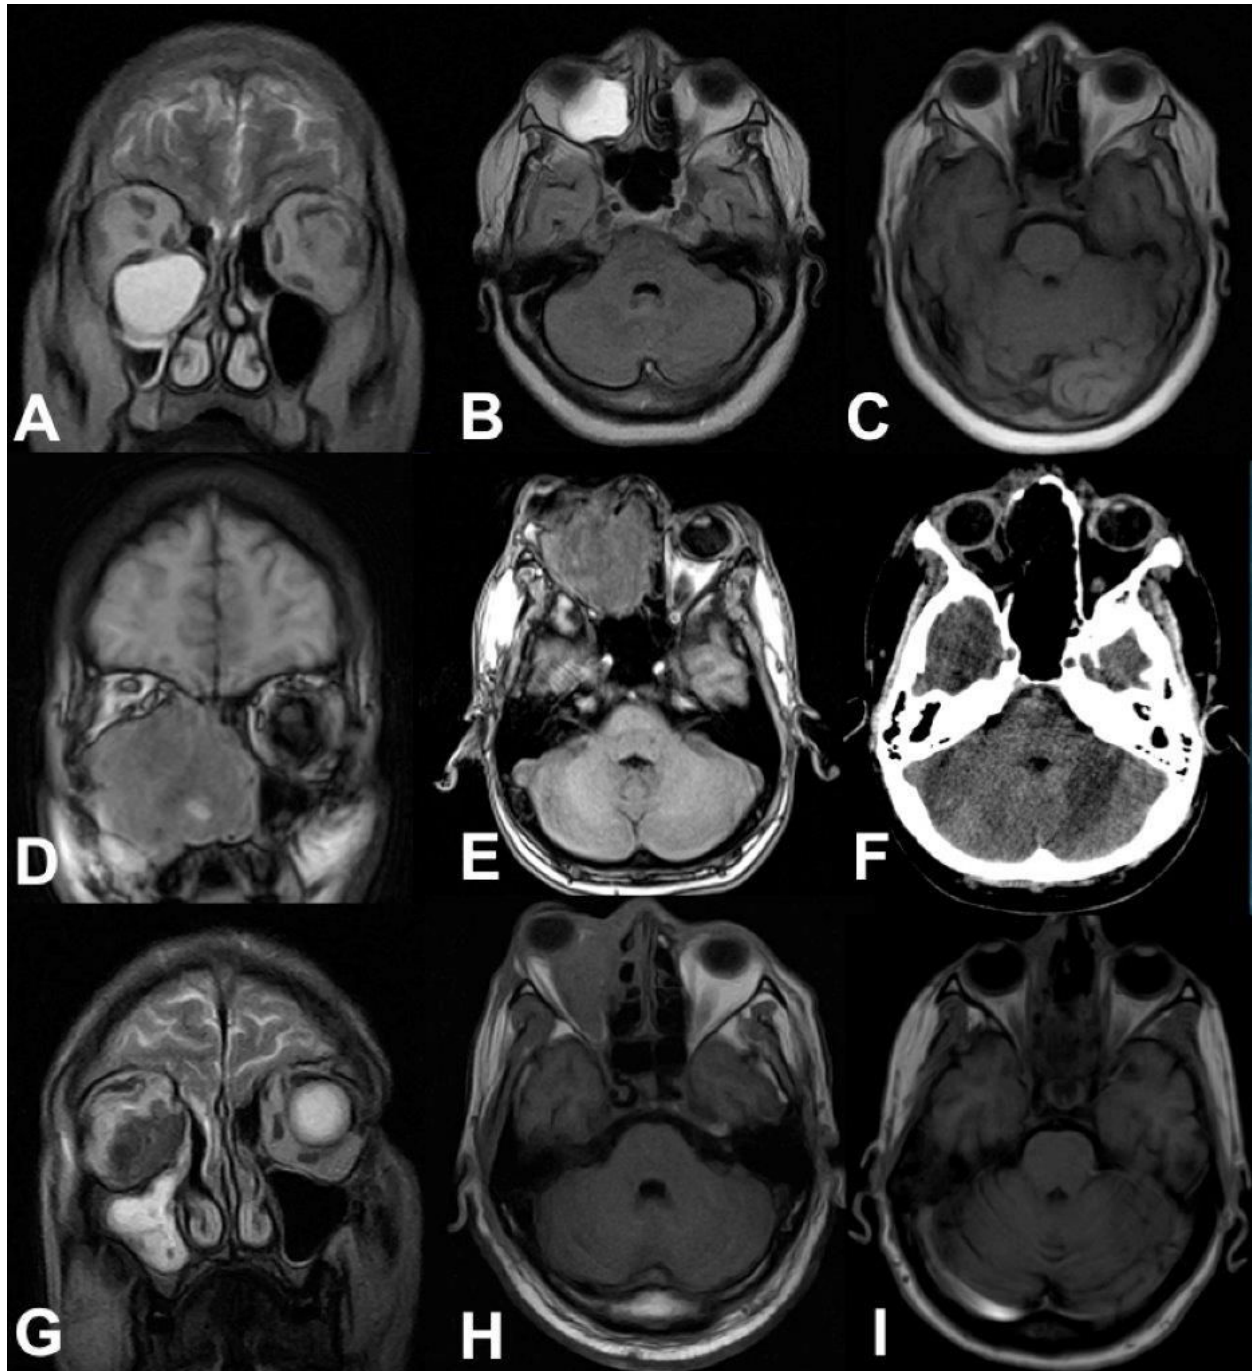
Preoperative and postoperative images of representative cases. A-B: preoperative coronal T2WI and axial T1WI RMI of patient number 4 with ethmoidal mucocele. C: postoperative T1WI RMI total removal of the mucocele. D-E: preoperative coronal and axial T1WI of patient number 1 with alveolar rhabdomyosarcoma. F: in postoperative CT scan a total resection of the lesion and medial orbital wall removal may observe. G-H: preoperative coronal T2WI and axial T1WI of patient number 3 with intraconal pseudotumor. I: postoperative CT scan shows a near-total removal of the lesion.
